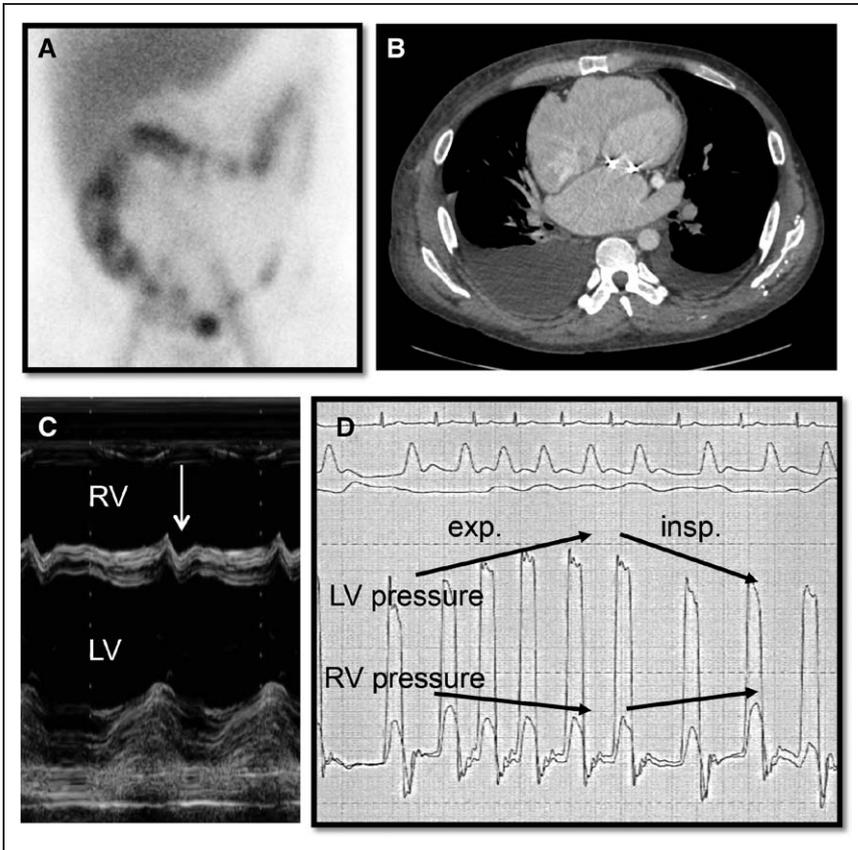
Imaging studies. A, Abdominal scintigraphy 6 h after intravenous administration of technetium-99 m–labeled human serum albumin, in which clear colonic tracer accumulation is present. B, Contrast-enhanced computed tomography revealing bilateral pleural effusion and thickened pericardium. C, Septal dip (arrow) in early diastole in M-mode echocardiography. D, Simultaneous pressure recording of the right and left ventricles (RV and LV, respectively) revealing equalization of the end-diastolic pressures with dip and plateau patterns, with respiration-dependent discordance in biventricular systolic pressures. exp. indicates expiration; and insp., inspiration.
